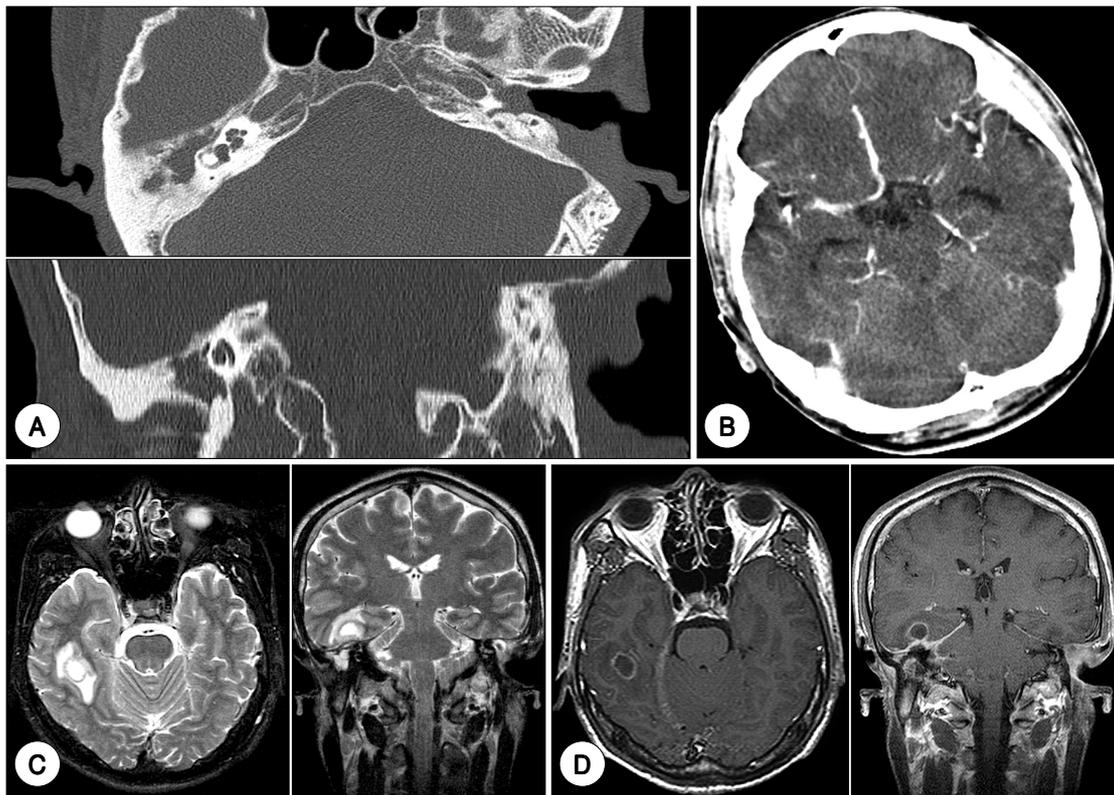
Imaging study in a case of brain abscess (case 7). A : Temporal bone CT ; Total haziness in right mastoid cavity and tegmen erosion are seen, B : Brain CT (enhance) ; There is no abnormal enhancement in brain parenchyma, C : Brain MRI, T2-weighted image ; Irregular high signal lesion in right temporal lobe is seen, D : Brain MRI, T1-weighted contrast image ; Low signal lesion with thin rim enhancement in right temporal lobe is seen.
